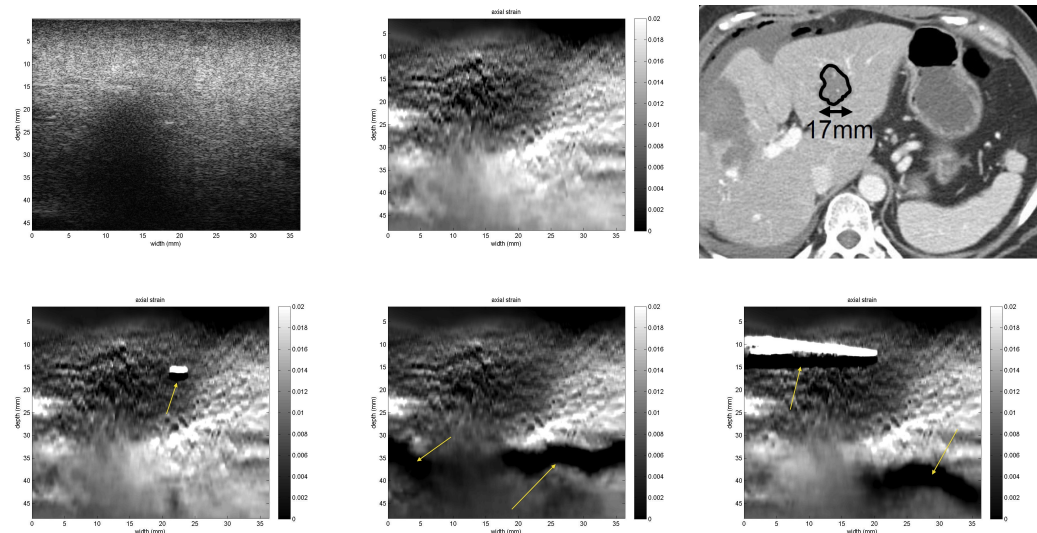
RF ablation therapy of liver cancer patient 1. All imaging was acquired after the ablation. B-mode (a), Elastography with the robust method (b) - The thermal lesion shows in as dark, surrounded by normal tissue in white., CT with delineated thermal lesions (c) and Elastography without the robust method (d-f).
